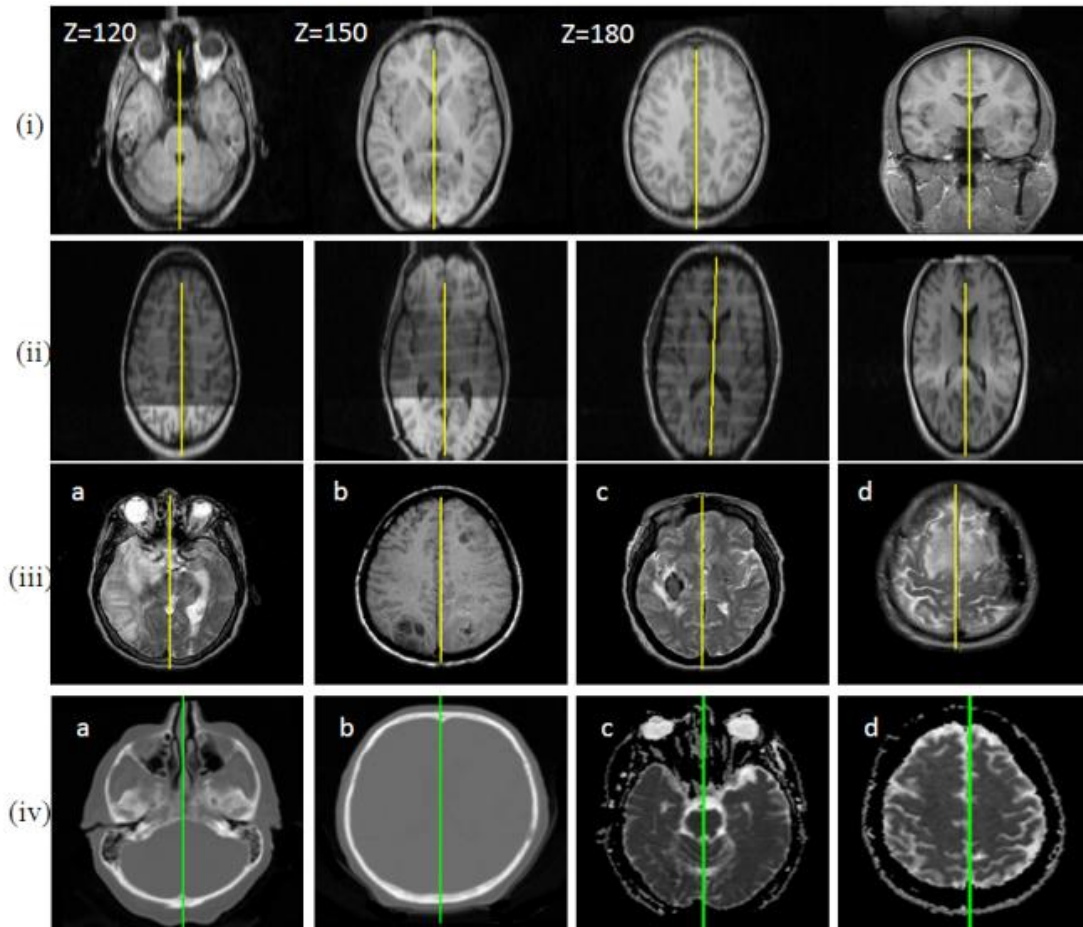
Estimated MSPs projected at axial/ coronal slices. (i). A single image at different axial locations and a coronal slice. (ii). Normal brain images taken from different subjects. (iii). Pathological images. (a). Stroke. (b).Sarcoma. (c).Haemorrhage. (d). Meningioma. (iv). Tested also on CT (a and b) and DWI (c and d).
